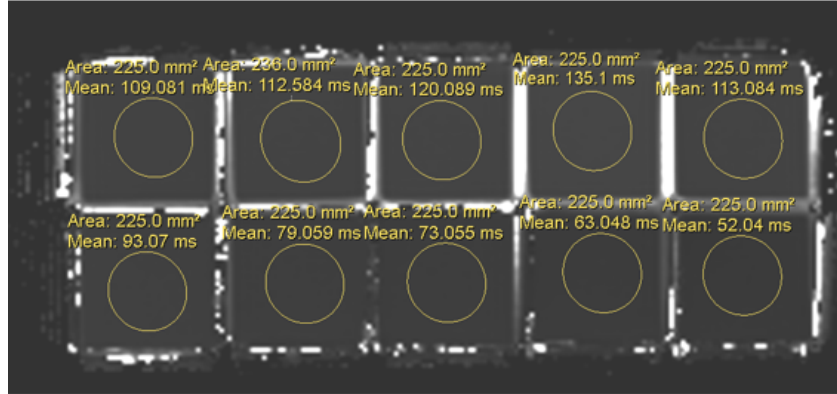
T2 values for regions of interest, as calculated by the scanner for Test A: PVA-c samples with copper sulphate added for MRI contrast
